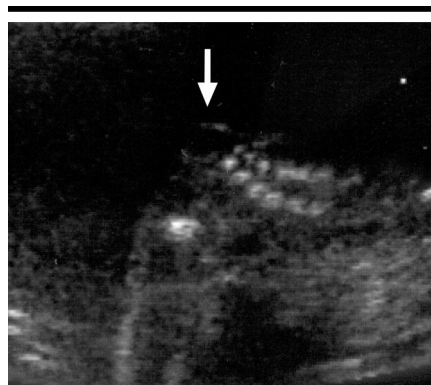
Transverse cranial sonogram of an 18-week-old fetus demonstrates the normal contour of a fetal skull.
